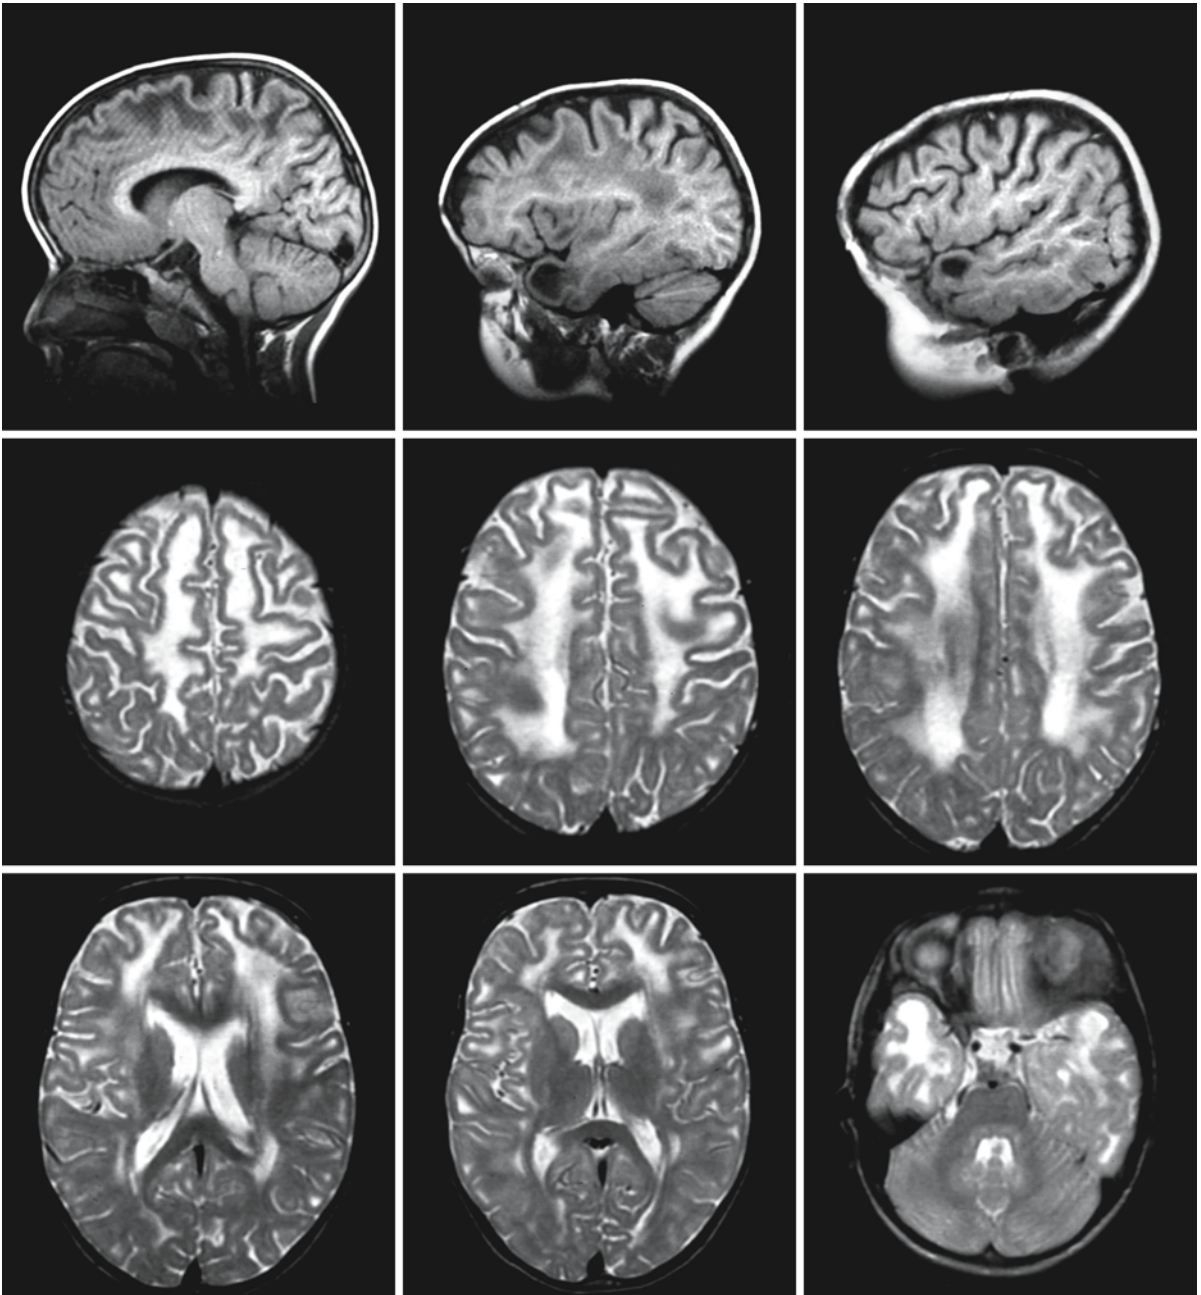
a. Girl with DNA-confirmed MLC. The first MRI (a) was obtained at the age of 5 years; the second (b) at the age of 11 years. Whereas the first images show a classical pattern
